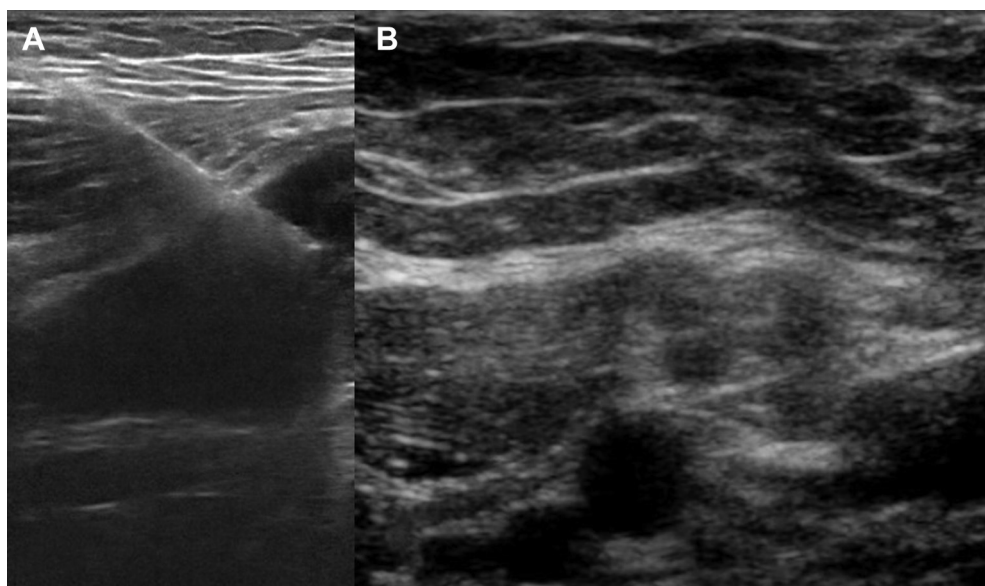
Image (A) demonstrates an ultrasound-guided biopsy. The mass appears heterogeneously hyperechoic on ultrasound (B).
